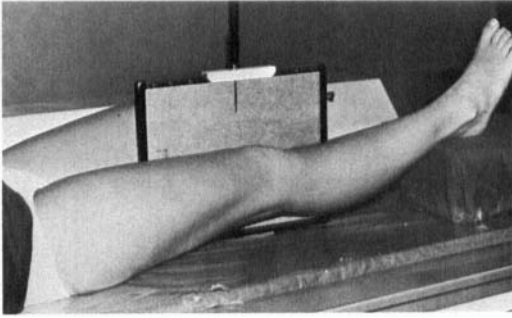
Position of the patient for roentgenographic measurement of the vertical position of the patella. The elevated heel allows extension of the knee.
